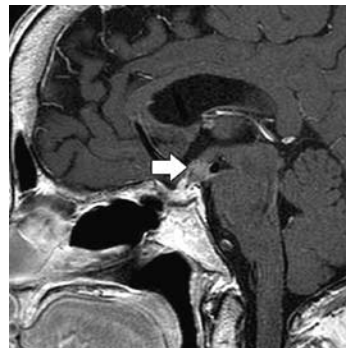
T1-weighted MR image with contrast medium demonstrated an enhanced sellar tumor with cystic component (white arrow).
